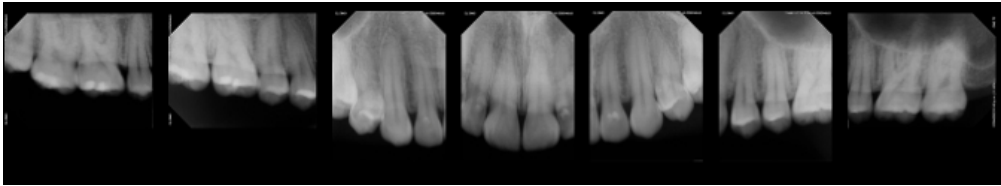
Periapical radiographs
